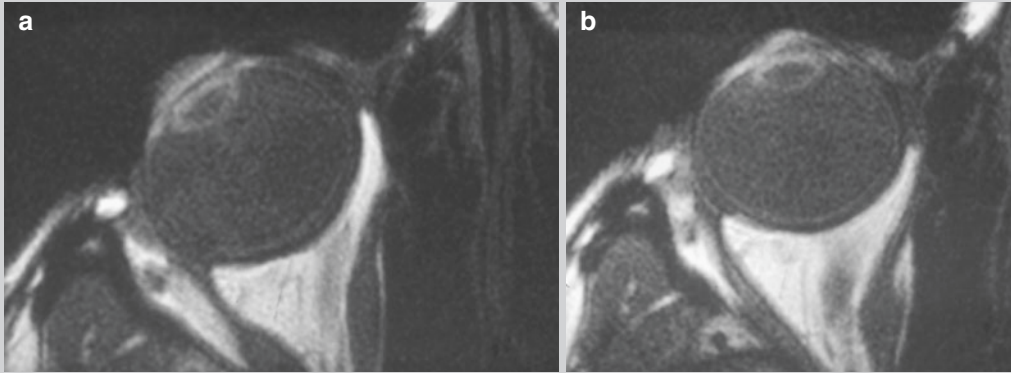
Multipositional MRI of the patient shown in Fig. 11.4 at 21 years of age. (a) Patient looking to her right. The right medial rectus is not attached to the globe and inserts on the medial orbital wall. (b) On
